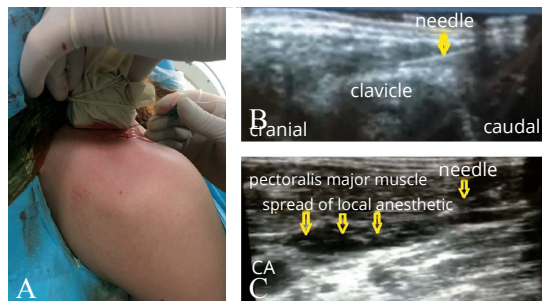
A) Block performing under aseptic conditions. A high frequency 12 MHz linear US probe with a sterile sheath was placed on anterior border of the medial third of the clavicle. A 22-gauge 50-mm block needle was inserted in a caudal to cephalic direction; B) sonographic anatomy and needle direction; C) spread of local anesthetic. CA: carotid artery.
